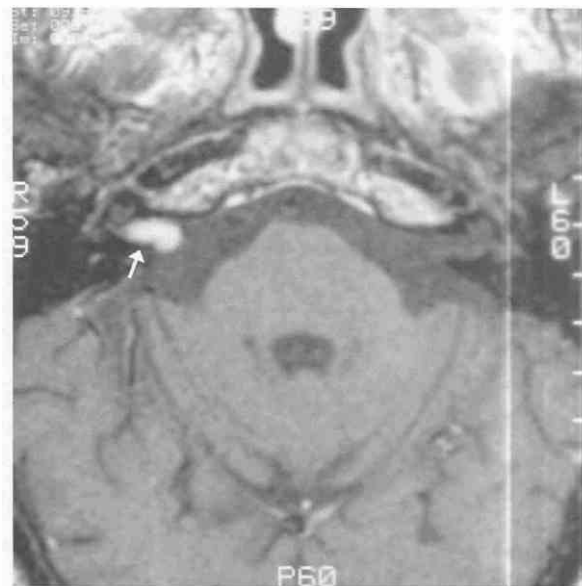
Vestibular schwannoma. Axial T1-weighted image of the posterior fossa and skull base following intravenous administration of gadolinium. A small intensely enhancing intracanalicular ovoid mass protrudes slightly medially into the cerebellopontine angle cistern on the right (arrow).
